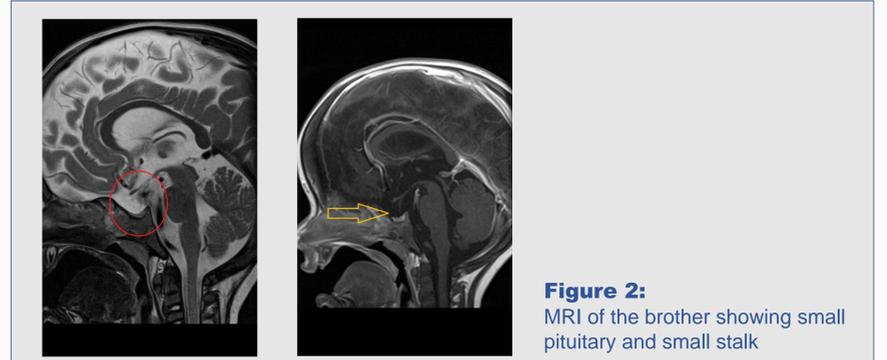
MRI of the brother showing small pituitary and small stalk
